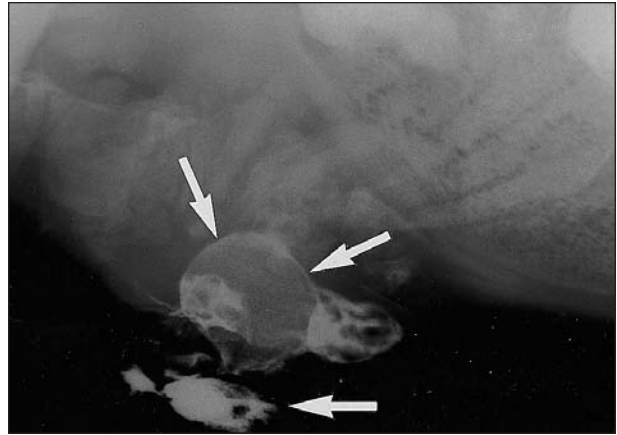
Lateral radiographic view of the caudal region of the sternum of the llama described in Figure 1, obtained after injection of 15 ml of diatrizoate meglumine and diatrizoate sodium into the draining tract. Notice the contrast material surrounding the circular bony opacity and within the draining tract (arrows). The tract does not communicate with the thoracic or abdominal cavities.
